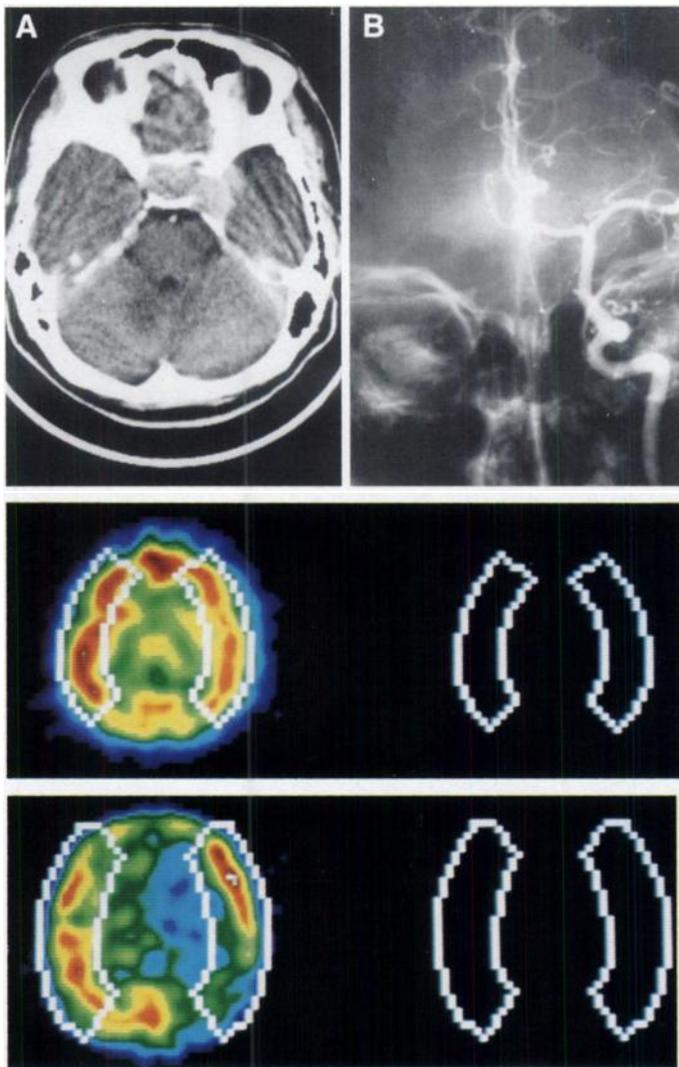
A 16-yr-old boy with pituitary adenoma. (A) Axial T1 weighted MR image shows pituitary tumor encircling the right internal carotid artery with extension to right parasellar area. (B) Carotid angiogram on AP projection shows good visualization of contralateral middle cerebral artery through the anterior communicating artery during left carotid compression. (C) Preocclusion brain SPECT shows no significant radioactivity difference between the cerebral hemispheres. (D) Postocclusion brain SPECT shows markedly decreased perfusion on the right cerebral hemisphere. Semiquantitative analysis revealed more than 15% perfusion deficits.
